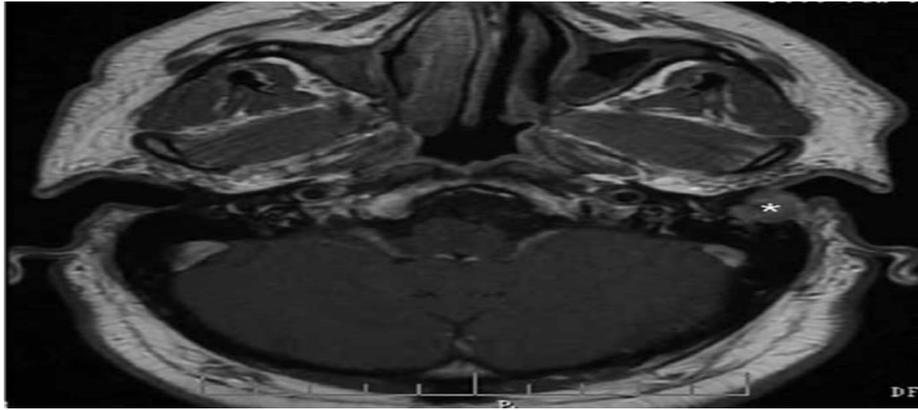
Axial contrast-enhanced T1 MRI of the tumor on the left external auditory canal
